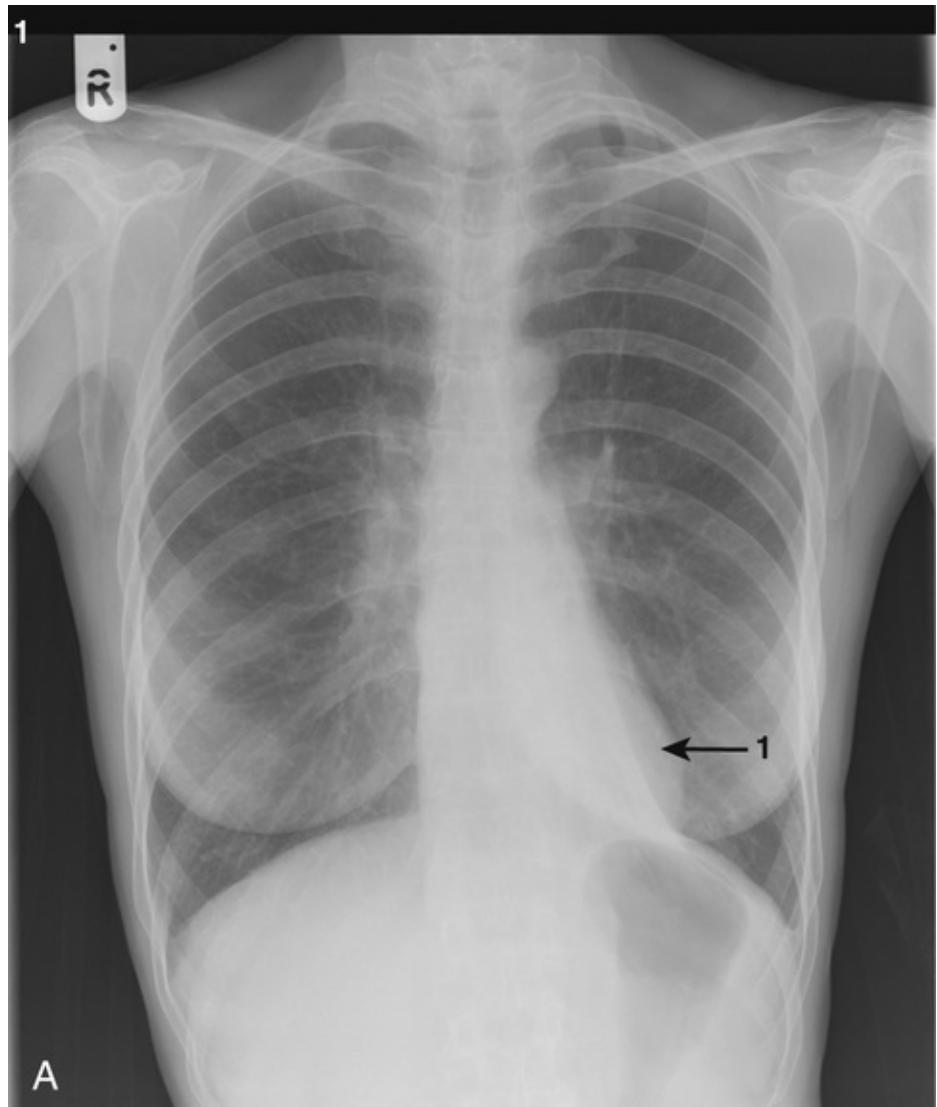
Left upper lobe collapse. (A) This is difficult to spot. Remember that most of the left upper lobe lies in front of, as opposed to above, the left lower lobe. When it collapses it causes a haze to appear over the whole of the left lung field. (B) The CT image shows the midpoint of the mediastinum shifted to the left (1). The left upper lobe bronchus is filled by a soft tissue density: a tumour (2). The diagnosis can be easily achieved at bronchoscopy.
